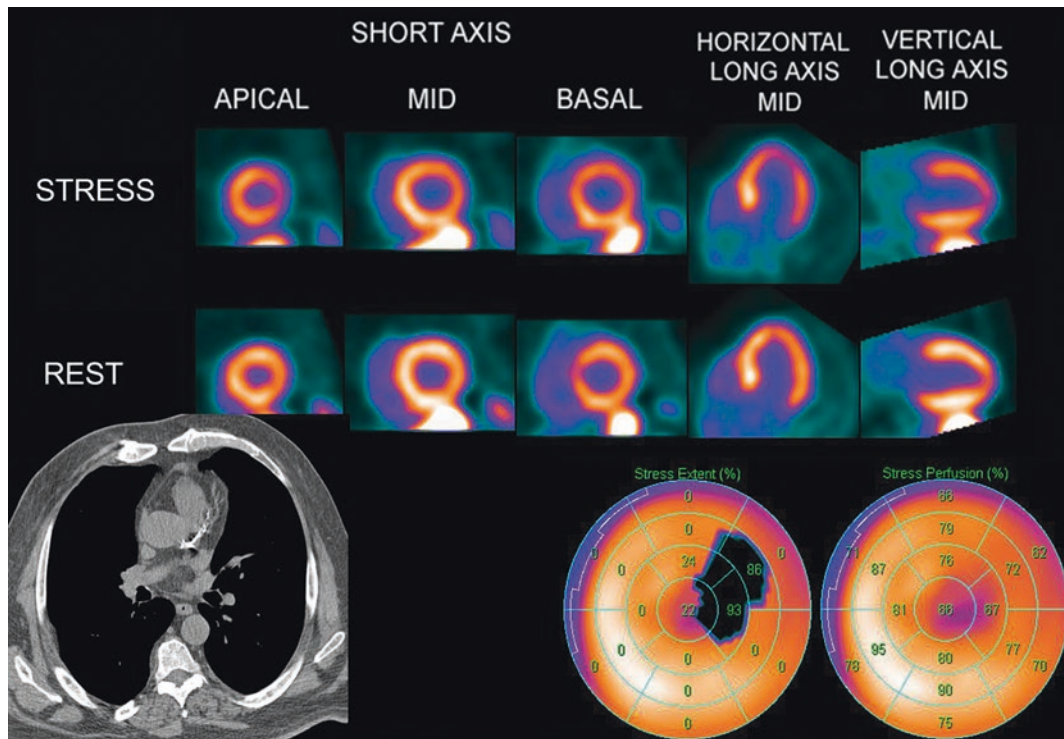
Case example of combined SPECT MPI and coronary artery calcium (CAC) scanning. The patient was a 57-year-old man who presented with typical anginal symptoms. The SPECT MPI study revealed a mild, reversible perfusion defect in the mid and distal anterolateral segments (summed stress score [SSS] = 3). On the basis of perfusion alone, this result would be considered probably abnormal. The CAC
